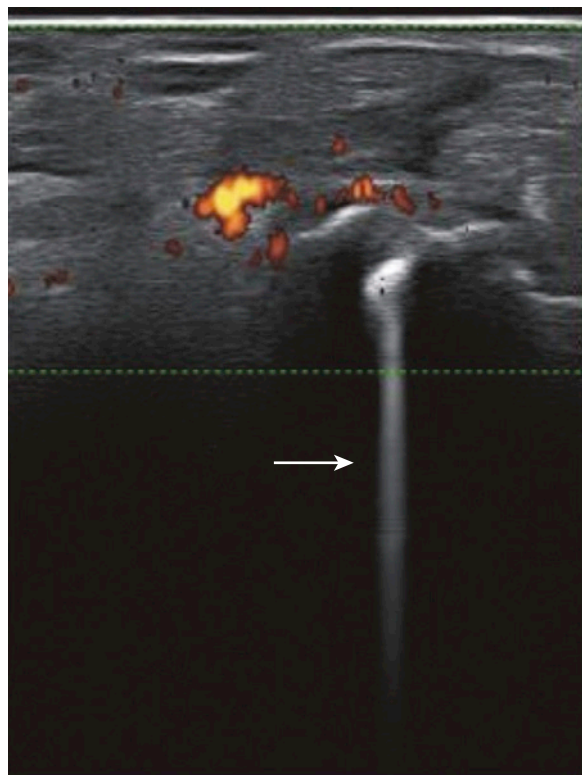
Ultrasound shows a streak artifact (arrowhead).
